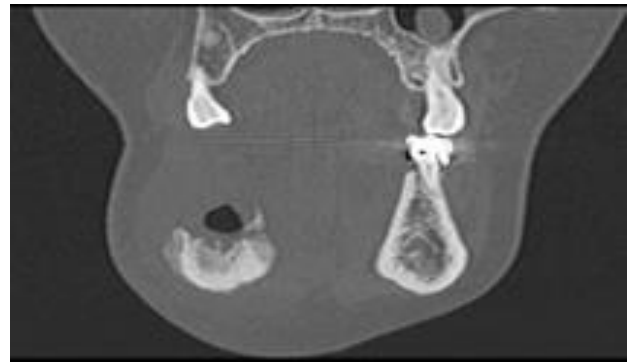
The sagittal view of the CBCT scan. Bone destruction without clear demarcation is found
